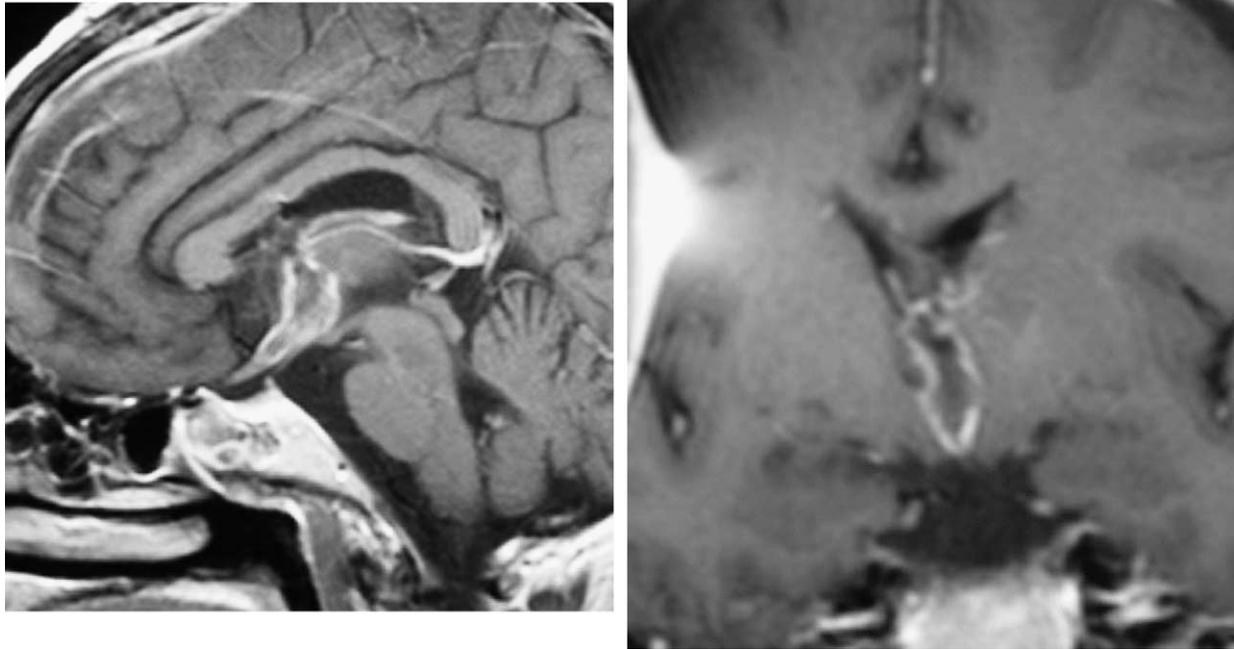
Postoperative T1-weighted magnetic resonance imaging after gadolinium-DTPA administration, taken two months after the operation, shows that the antero-inferior region of the third ventricle cavity is increased in size and with ring enhancement. Left: sagittal section. Right: coronal section.
